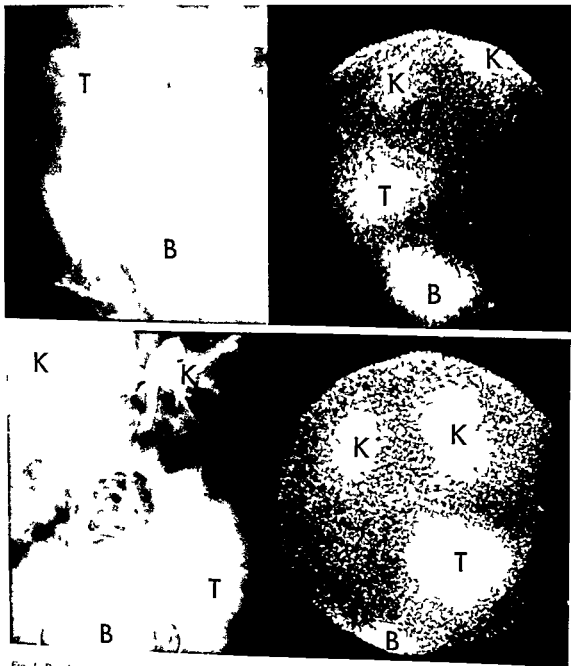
Renal transplants in a patient with Gaucher disease. Second (upper) and third (lower) renal grafts visualized with intravenous pyelography and radio isotope scintigraphy.
